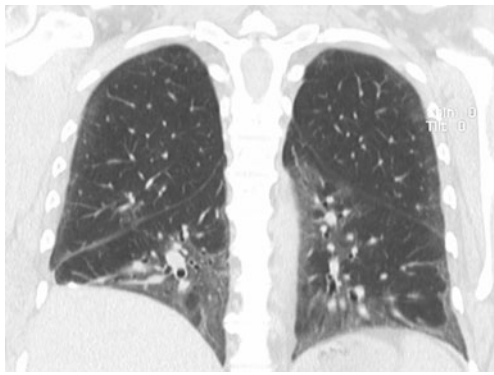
Coronal view slice from a HRCT scan from a 58-year-old woman with dermatomyositis. Notice the ground-glass opacities and traction bronchiolectasis characteristic of mixed cellular and fibrotic NSIP
